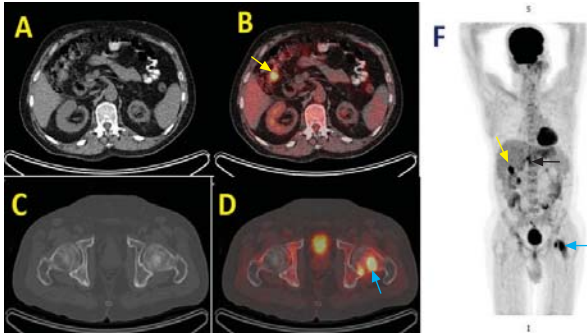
(A) Axial slice of NECT in soft tissue window; (B) ¹⁸FDG PET/CT Fused axial slice in soft tissue window; (C) Axial slice of NECT in bone window; (D) ¹⁸FDG PET/CT Fused axial slice in bone window; (F) Maximum Intensity Projection (MIP) image
